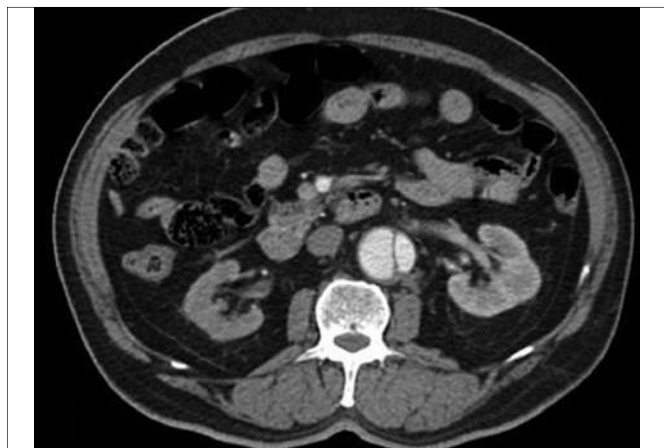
Axial contrast enhanced CT showing malperfusion of the right kidney.
